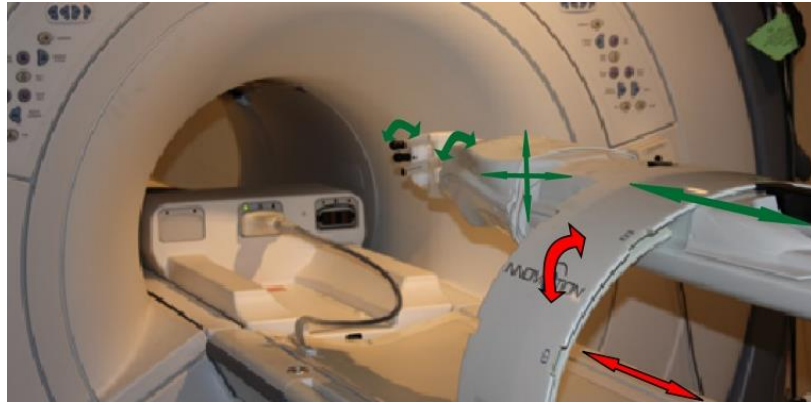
Front view of the robotic arm in front of a 1.5T MRI scanner, 5 degrees of freedom of the INNOMOTION robot (green arrows) and two manual DOF (red arrows);
